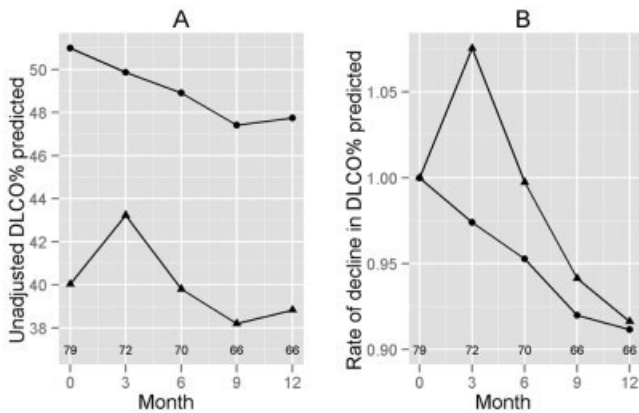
A, Decline in the diffusing capacity for carbon monoxide (DLCO) % predicted values over 12 months, according to high-resolution computed tomography–defined maximum fibrosis scores (● = 0–2; ▲ = 3–4). B, Rate of decline in DLCO % predicted adjusted for the baseline DLCO % predicted. Values above the x-axis represent the numbers of patients corresponding to the data points for the given months.
